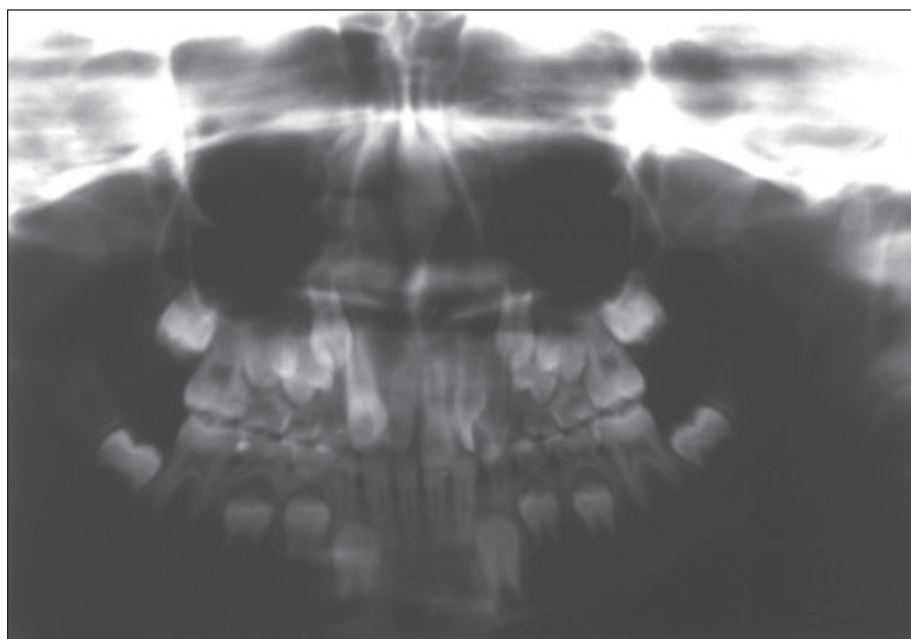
Panoramic radiograph of case 2 before treatment.
